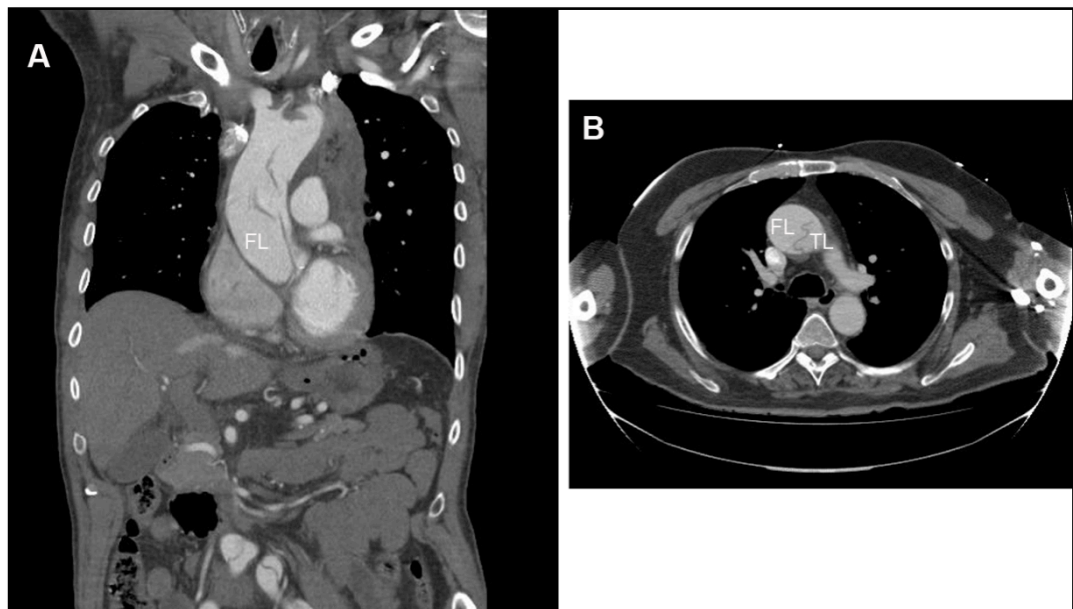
CT ANGIOGRAM (A&B) IMAGES FROM A PATIENT WITH ACUTE TAAD. YELLOW ARROW INDICATES POSITION OF INTIMAL FLAP. FL= FALSE LUMEN, TL= TRUE LUMEN.
